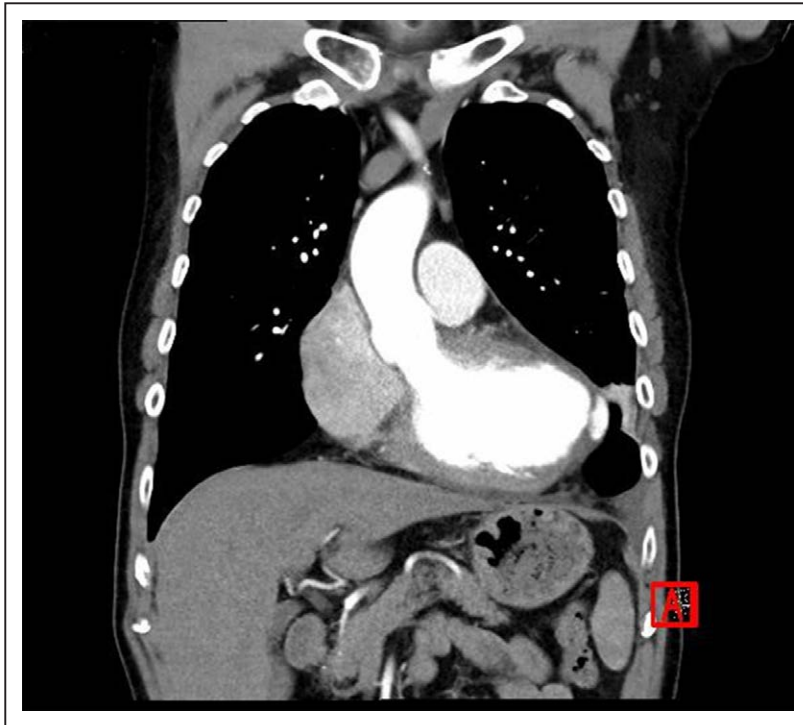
Giant left ventricular aneurysm with apical perforation (computed tomographic [CT] scan).
